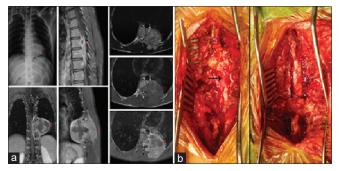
(a) X-ray and magnetic resonance imaging Thoracic spine showing T2 hypointense and T1 contrast-heterogeneously enhancing lesion extradurally compressing dural sac with extension into thoracic cavity. (b) Intraoperative picture showing lesion extradural in location encasing thecal sac. Postoperative complete removal of lesion. (Black arrow showing lesion)
